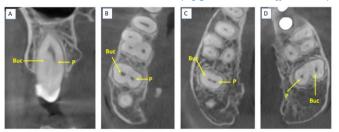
CBCT scans (Romexis software) provide a detailed view of the region of interest from multiple perspectives: axial (A), sagittal (B), and coronal (C) views. The images reveal the presence of palatal (P) P1 and P2 canals with a type IV configuration in both right and left maxillary first molars. Notably, the palatal canals converge to form a single canal at the midpoint of the root (B and C).
